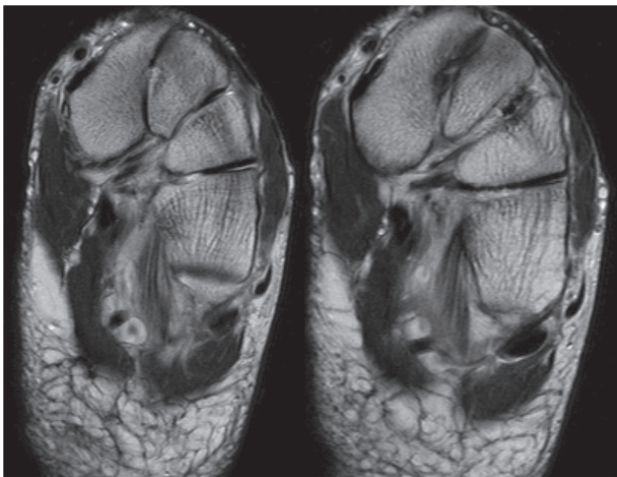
Consecutive axial T2-w MR images.
